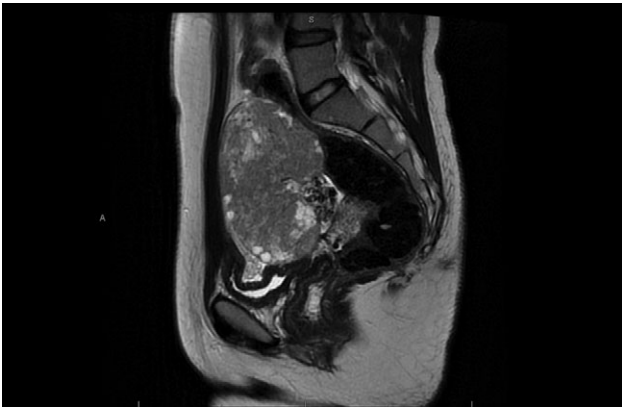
CT scan showing large right sided heterogeneous lesion 10 × 10 × 7 cm<sup>3</sup>.
